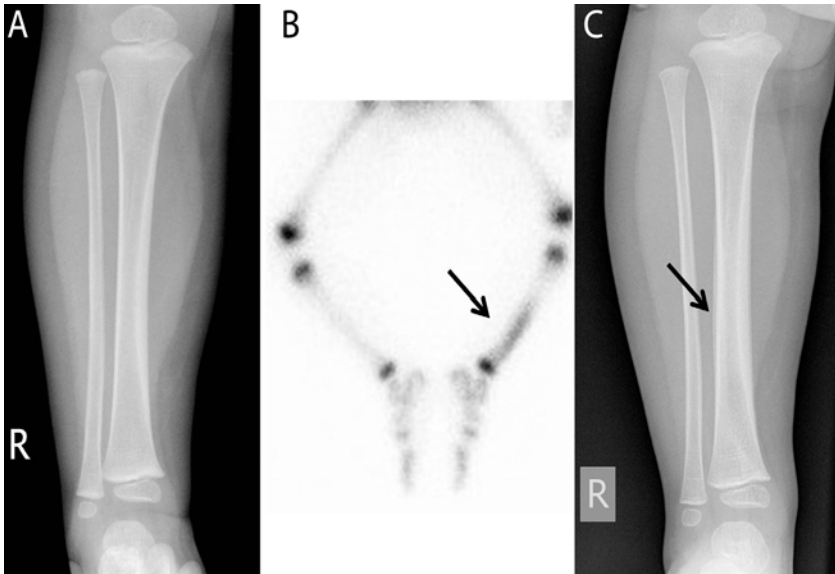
(A) Anteroposterior radiograph of the tibia at the initial presentation on the side of the limp. No abnormality is apparent. (B) Bone scan shows obvious increased uptake in the distribution of the right tibia. (C) After four weeks a florid periosteal reaction can be seen, which supports the diagnosis of toddler's fracture
